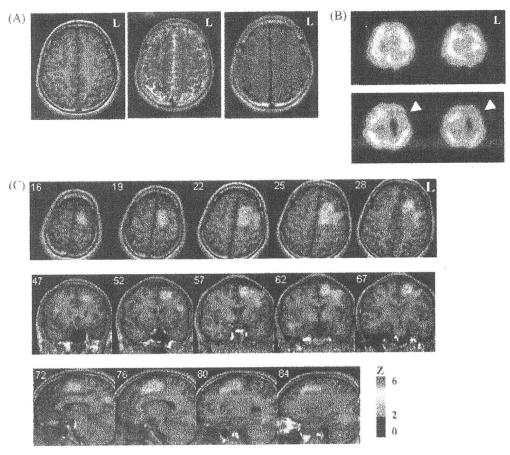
MRI, co-registered IMZ-SPECT and 3D-SSP analysis. (A) T1-, T2-weighted and FLAIR MR axial images were unremarkable. (B) MRI co-registered SPECT showed normal uptake after 30 min from injection (upper panel). 3 h after injection, decreased uptake was identified on the left frontal region (lower panel, white arrowhead). (C) 3D-SSP shows the area with significant decreased uptake on the medial aspect of the left frontal region.
